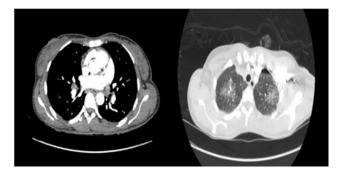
CT of the chest with IV contrast in axial lung view. Multiple enlarged mediastinal and para-tracheal lymph nodes. Patchy groundglass consolidations in bilateral upper lobes
